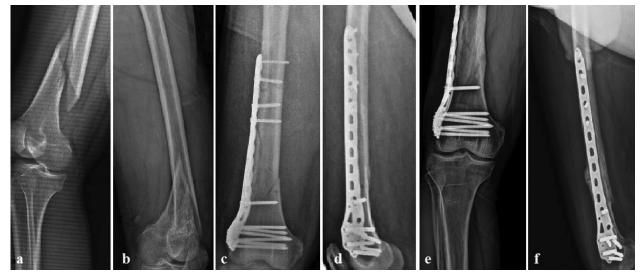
(a and b), Preoperative anteroposterior and lateral radiographs of a 52-year-old women with type A2 distal third femoral fracture; (c and d) early postoperative radiograph of distal third femoral fracture managed by locking plate; (d and f) Follow up radiograph at 18 weeks showing fracture consolidation
